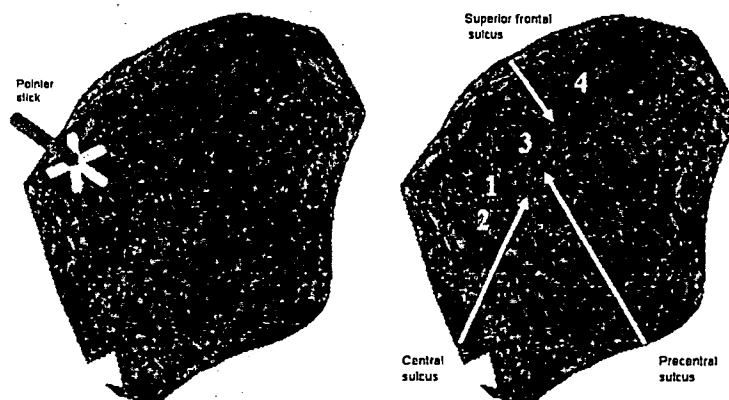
The navigation system can superimpose the location and angle of the coil in relation to the cortical surface of an individual in real time on their MRI with high anatomical accuracy. The precentral gyrus (M1) (1), and postcentral gyrus (S1) (2) both representing hand areas, the premotor area (3) and the supplementary motor area (SMA) (4) are selected as typical target examples. A superimposed pointer stick represents the center of the figure-eight coil and demonstrates not only the location but also the angle to the cortex surface of the coil in real time consistently on MRI of individuals.
